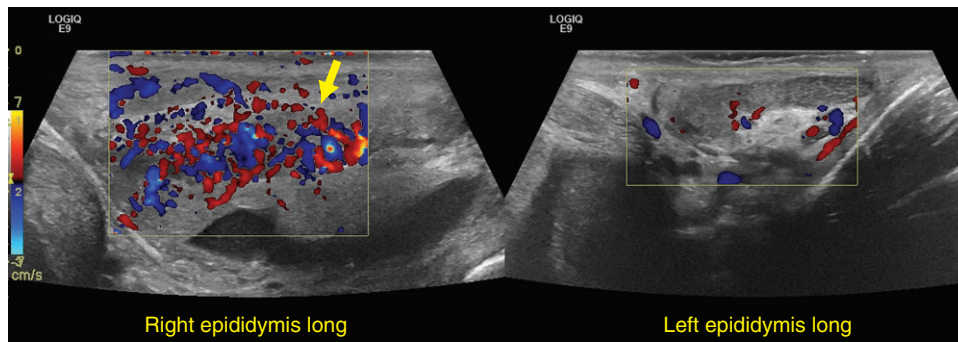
Color Doppler shows increased flow in the affected epididymis (arrow) as compared to the other side.
